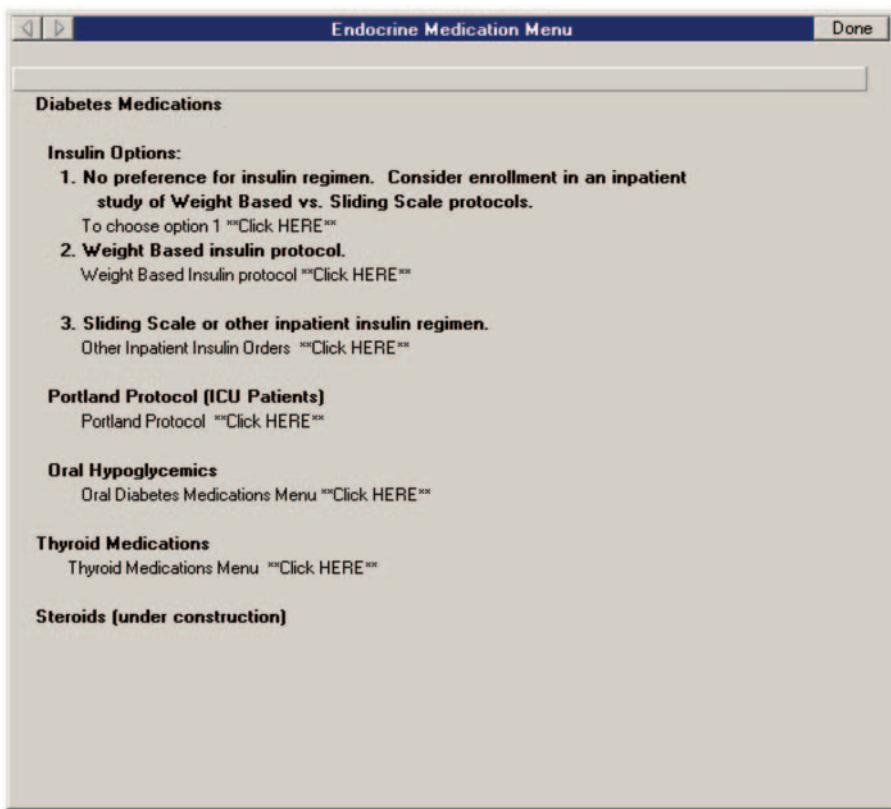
Screen shot of CPRS showing introduction of POC-CT option into the insulin options menu
